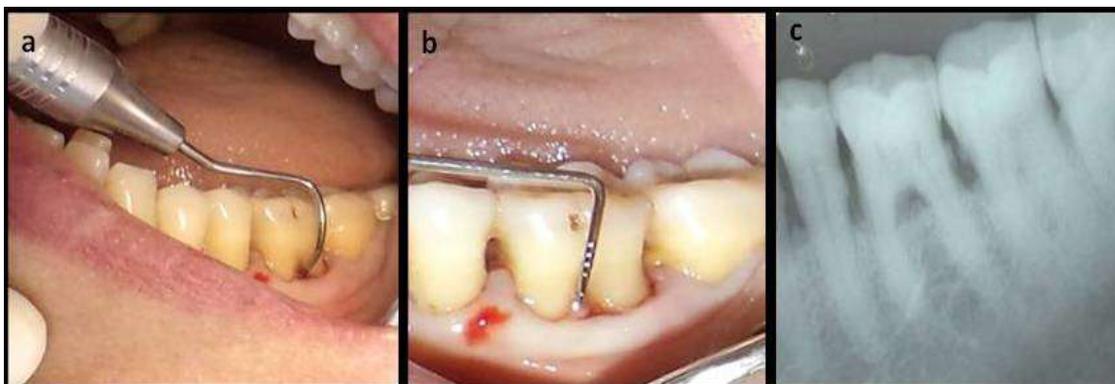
(a) 9 mm loss of horizontal clinical attachment when measure with Naber's probe, (b) 7mm loss of Buccally vertical attachment when measured with William's probe, (c) Radiographic image
